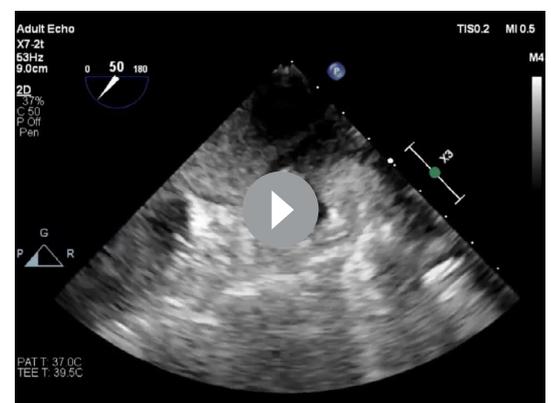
Upper left: 3D reconstruction of left atrium with visualisation of five pulmonary veins and absent appendage in the expected location. Upper right: 3D reconstruction of heart again demonstrating no evidence of atrial appendage. Lower left: representative transesophageal echocardiography image demonstrating fat in the transverse sinus (TVS) adjacent to the left superior pulmonary vein (LSPV). Lower right: representative CT image demonstrating absence of the left atrial appendage in the expected location.
